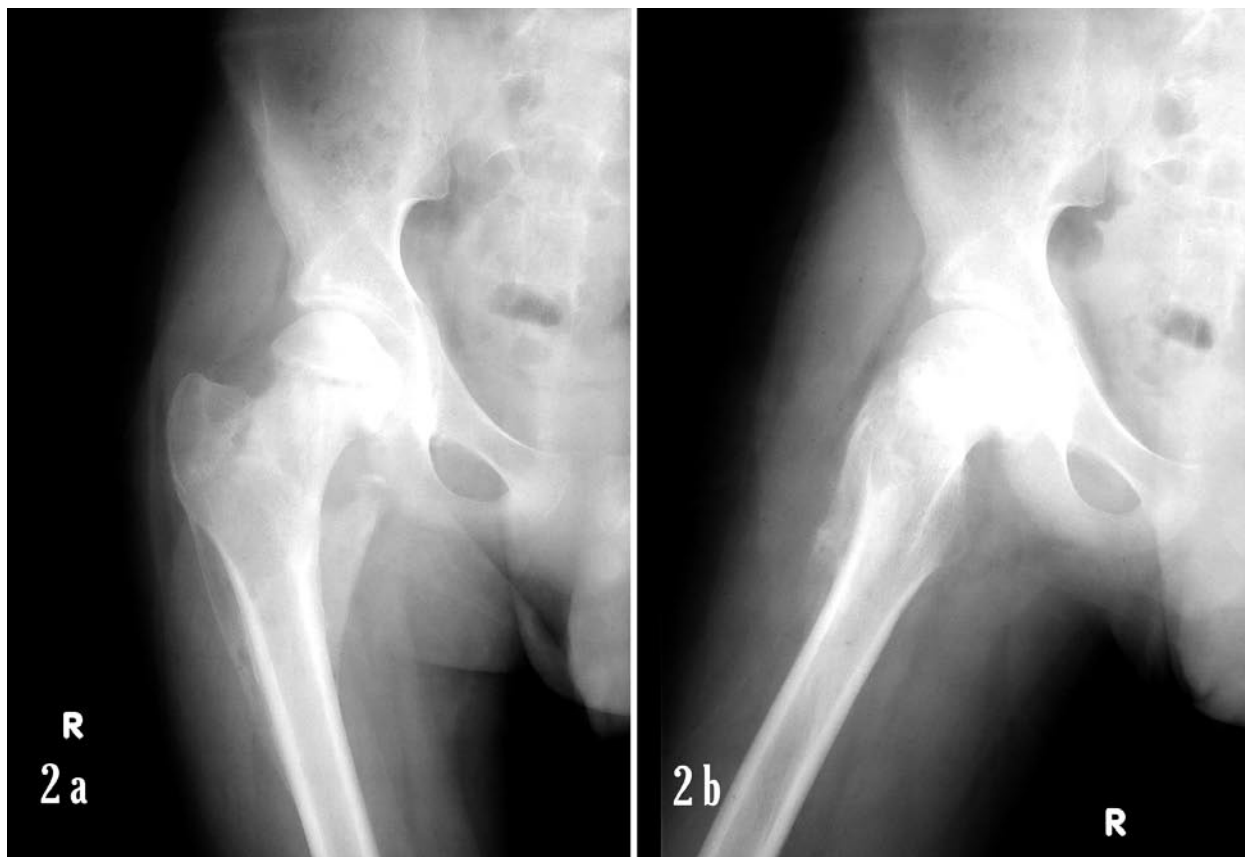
Anteroposterior (a) and lateral (b) radiographs of the right hip four months after injury, presenting healed avulsed fractures of the greater and lesser trochanter and viable head of the right femur
